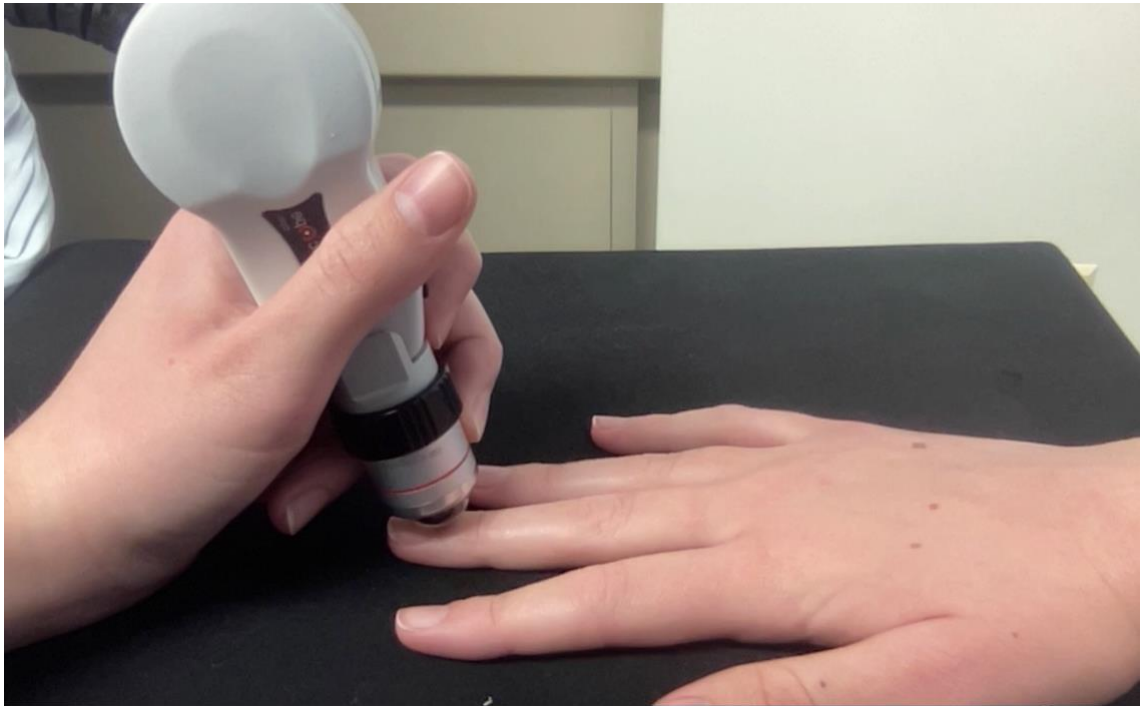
The INSPECTIS digital capillaroscope positioned on the nailfold of the third finger to take images of the nailfold capillaries.
